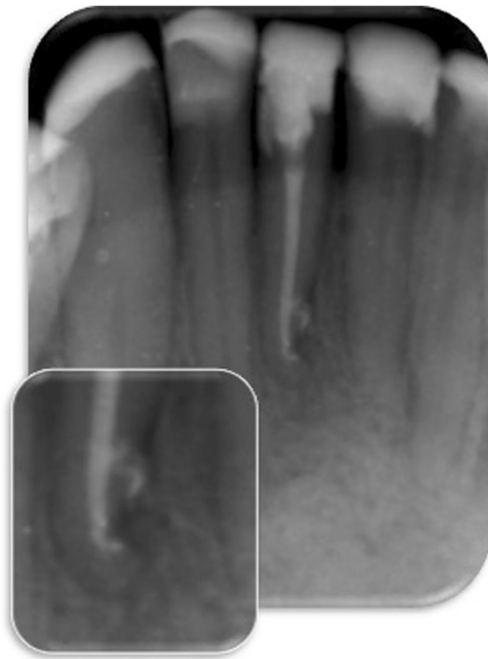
Case #1 radiographic assessment with a 12-month follow up. To be noticed is the complete regression of the AP and re-establishment of the periodontal structures
